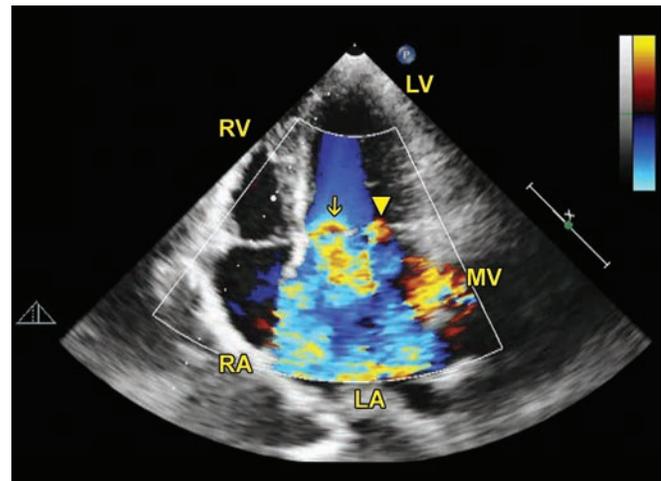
Color Doppler examination. Apical four chamber view demonstrating severe MR through the perforation (arrow) in the anterior MV leaflet.
